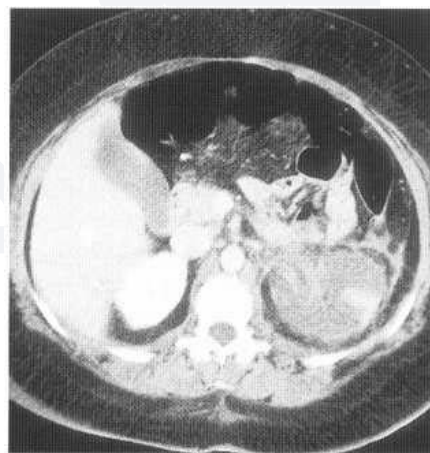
Contrast CT scan of a renal infarct in a patient with arteritis. The left kidney is almost entirely non-perfused apart from a partial peripheral rim.
